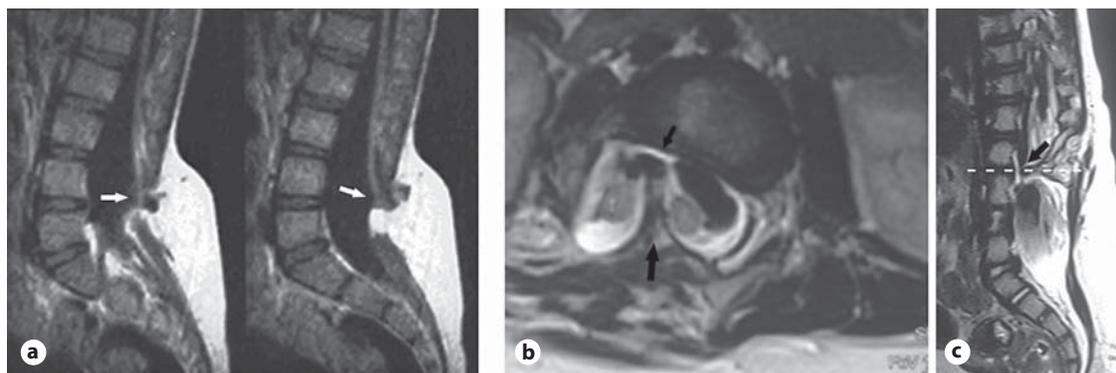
a Sagittal MRI view; subcutaneous lipoma mass with tethered cord (white arrows). b, c Axial and sagittal MRI view of a diastematomyelia; black arrows show bone spur.
